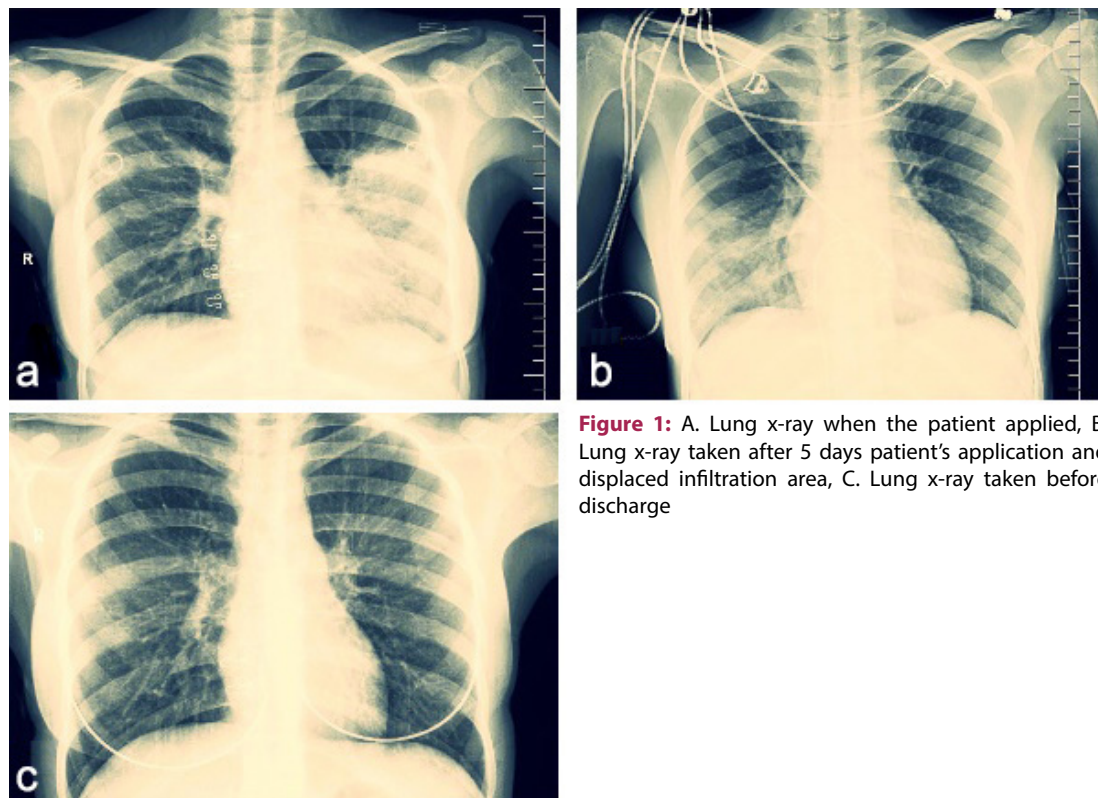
A. Lung x-ray when the patient applied, B. Lung x-ray taken after 5 days patient's application and displaced infiltration area, C. Lung x-ray taken before discharge
